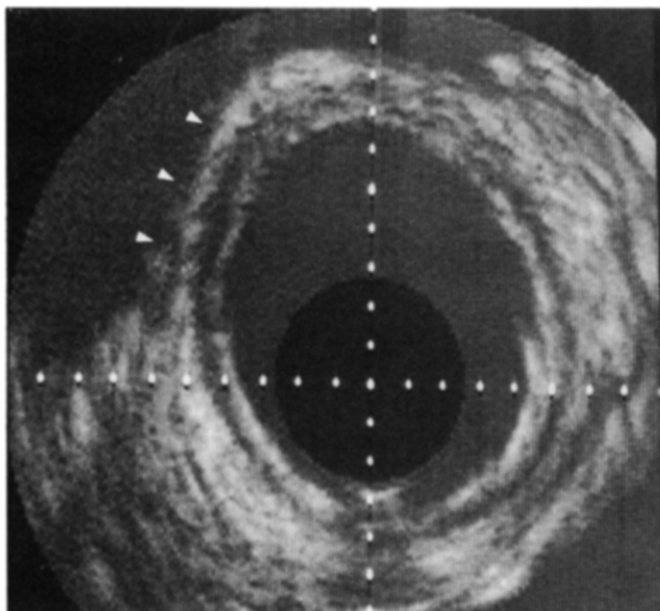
Ultrasound image of aorta in which adventitia has been completely dissected (arrowheads), demonstrating a thin outer echo-dense layer, a thick black middle layer and a thin inner echo-dense layer.
